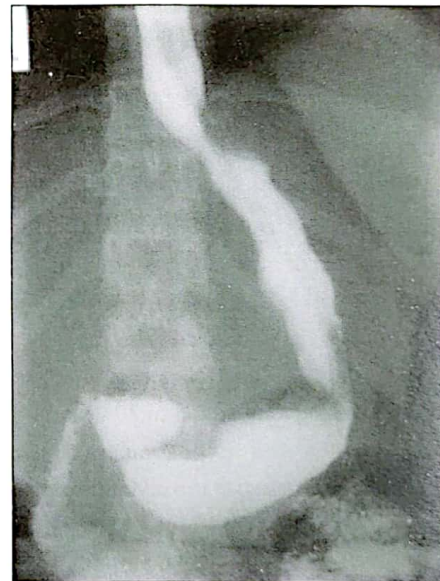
Post-operative X-ray underwent sleeve resection of the stomach.
